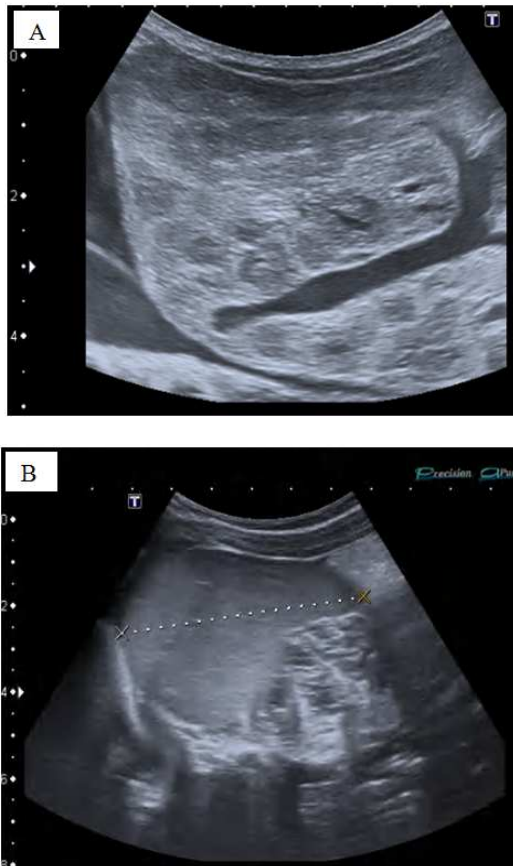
Liver ultrasound, A: before treatment, and B: after 3 months treatment with Propranolol.
